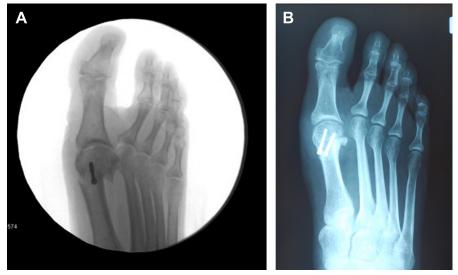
A 50-year-old woman with valgus malunion of the metatarsal head 2 months after an Austin osteotomy. (*A*) Preoperative AP radiograph. (*B*) AP radiograph at follow-up following reosteotomy and rotation of the distal fragment.
